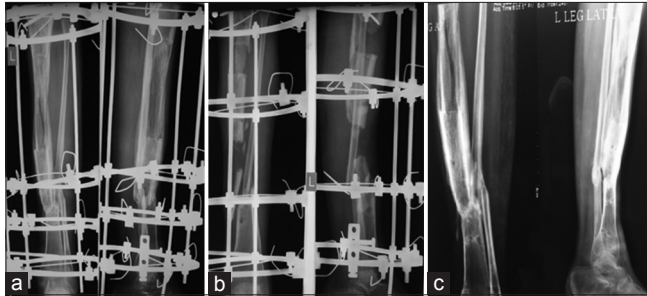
X-ray of patient with fixator during distraction and showing the regenerate (a), X-ray following docking (b), and after removal of fixator showing bony union (c)
